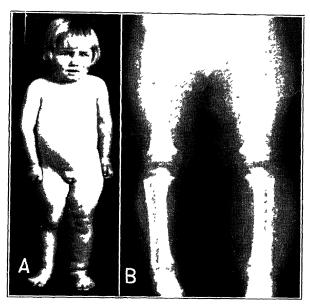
4, A 3-year-old patient with nonfamilial congenital lymphedema (lymphangiectasis) B, Roentgenogram showing lymphedema of the subcutaneous tissues of the left leg. (Cooperstock Am. J. Dis. Child.)
